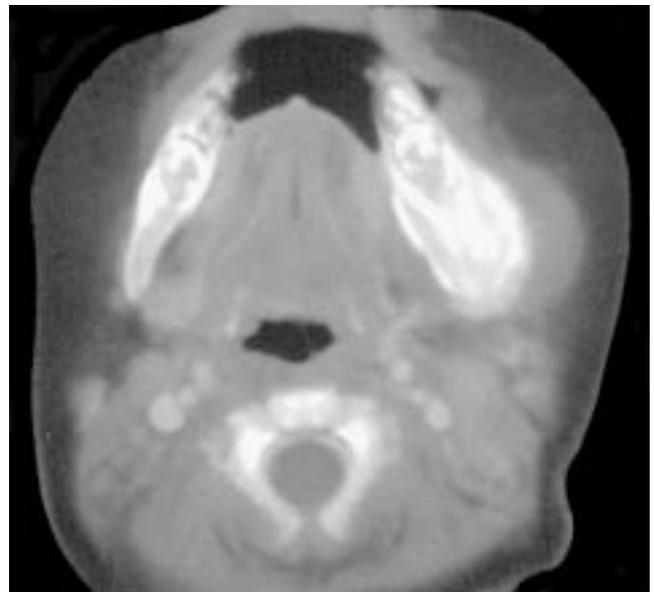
CT axial section of the mandible in a 6 month-old infant with Caffey's Disease demonstrated a localized periosteal laminated reaction in the angle of the mandible on the left (arrow). Associated adjacent soft tissue edema is also noted.
